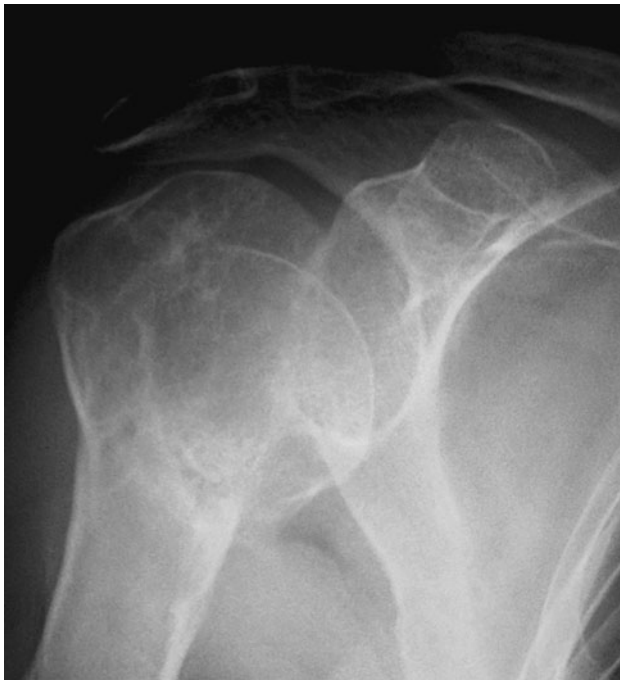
Preoperative AP radiographs of patient with a three-part proximal humeral fracture malunion. The greater tuberosity healed in a superior position in relation to the humeral head
